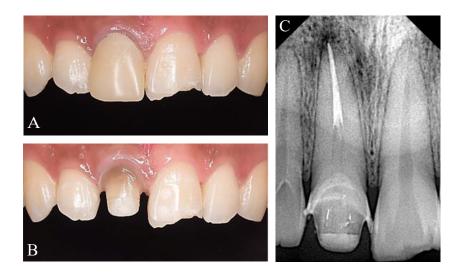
A. Preoperative view of an acrylic crown and damaged maxillary anterior teeth, B. View after acrylic crown removal, C. Initial periapical radiograph of involved teeth.
